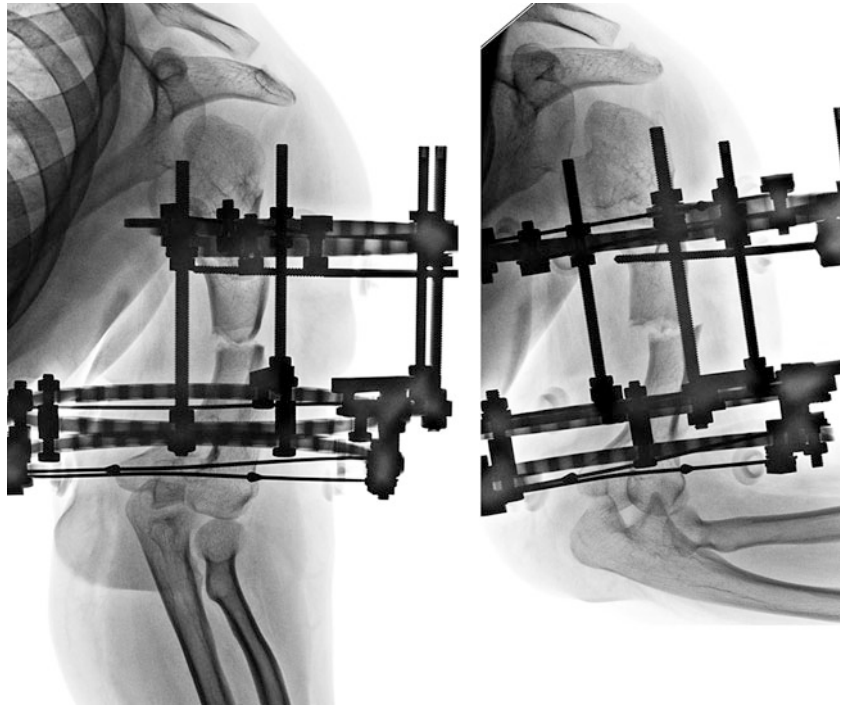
Postoperative AP and LAT radiographs at 2 months of distraction. Note typical three-zonal distraction regenerate and maintenance of bone fragment orientation during the lengthening
